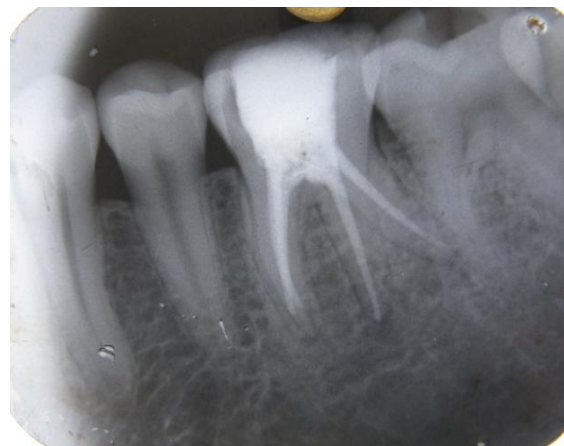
Radiograph of Obturation
